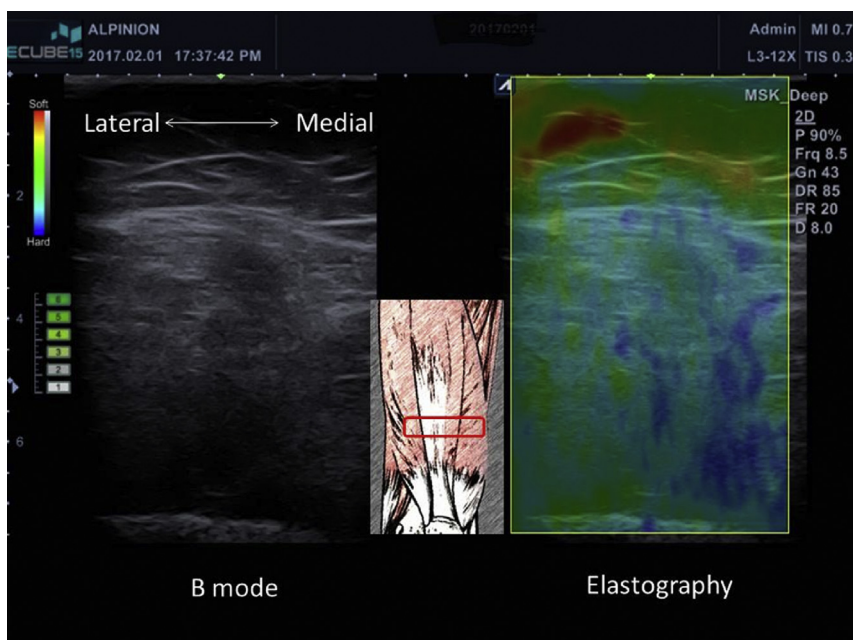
B-mode imaging (left) and elastography (right) of the lesion. The image was obtained by using an ultrasound machine equipped with a high frequency transducer and the function of elastography (Ecube 15; Alpinion, Seoul, Korea).
